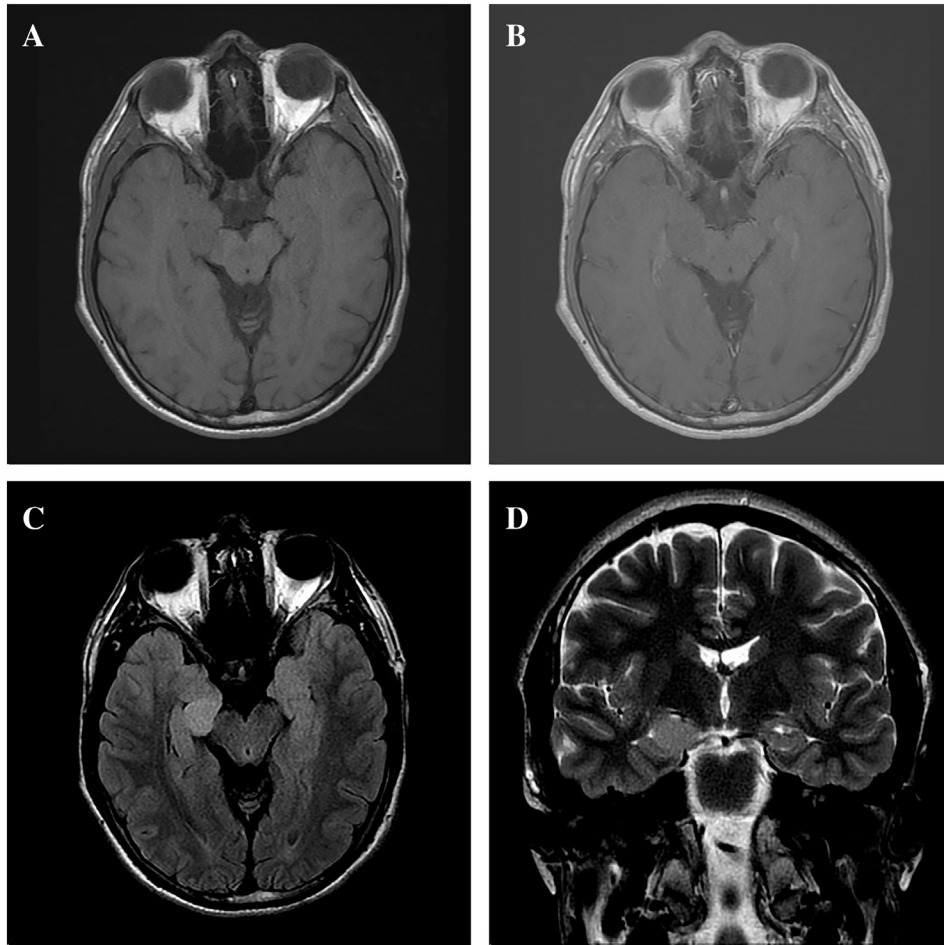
Mass-like nonenhancing lesion present within the right hippocampal head measuring $1.9 \times 1.6 \times 1.2$ cm. (A) Axial T1 pre-contrast. (B) Axial T1 post-contrast (C) Axial T2/FLAIR. (D) Coronal T2.
